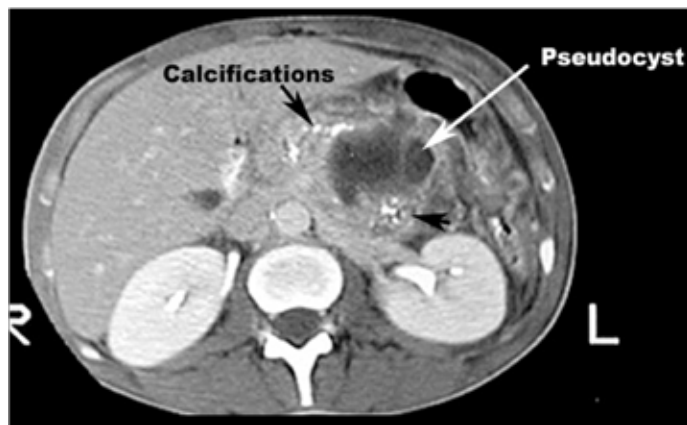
CT scan showing chronic pancreatitis with complications.
